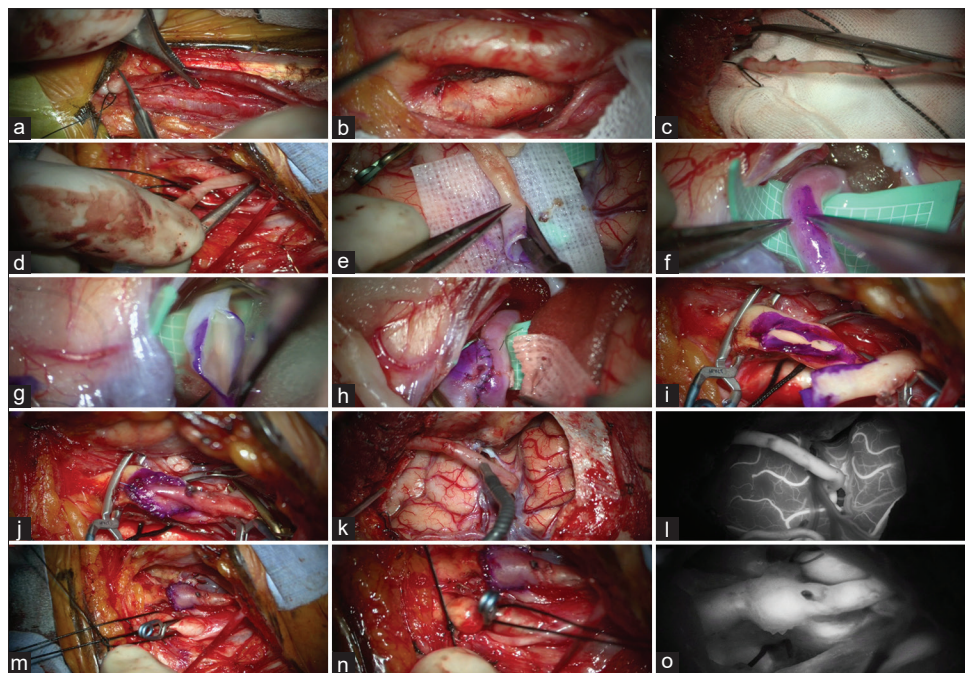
External carotid artery-radial artery graft-M2 bypass (a) harvesting left radial artery graft; (b) Exposing the distal left cavernous carotid aneurysms, proximal left external carotid artery and internal carotid artery; (c) and (d) Tunneling of the radial artery graft from cranial to neck; (e) Preparation of donor site of the radial artery graft; (f) Marking of M2 for arteriotomy; (g) Left middle cerebral artery M2 arteriotomy; (h) radial artery graft-M2 anastomosis; (i) Left external carotid arteriotomy; (j) End to side radial artery graft-external carotid artery anastomosis; (k) Checking the blood flow from radial artery graft to M2 using micro Doppler; (l) indocyanine green showing good flow from radial artery graft to the M2; (m and n) Double ligations of the proximal internal carotid artery; (o) indocyanine green showing blood flow within external carotid artery and external carotid artery - radial artery graft bypass with no flow in the internal carotid artery
